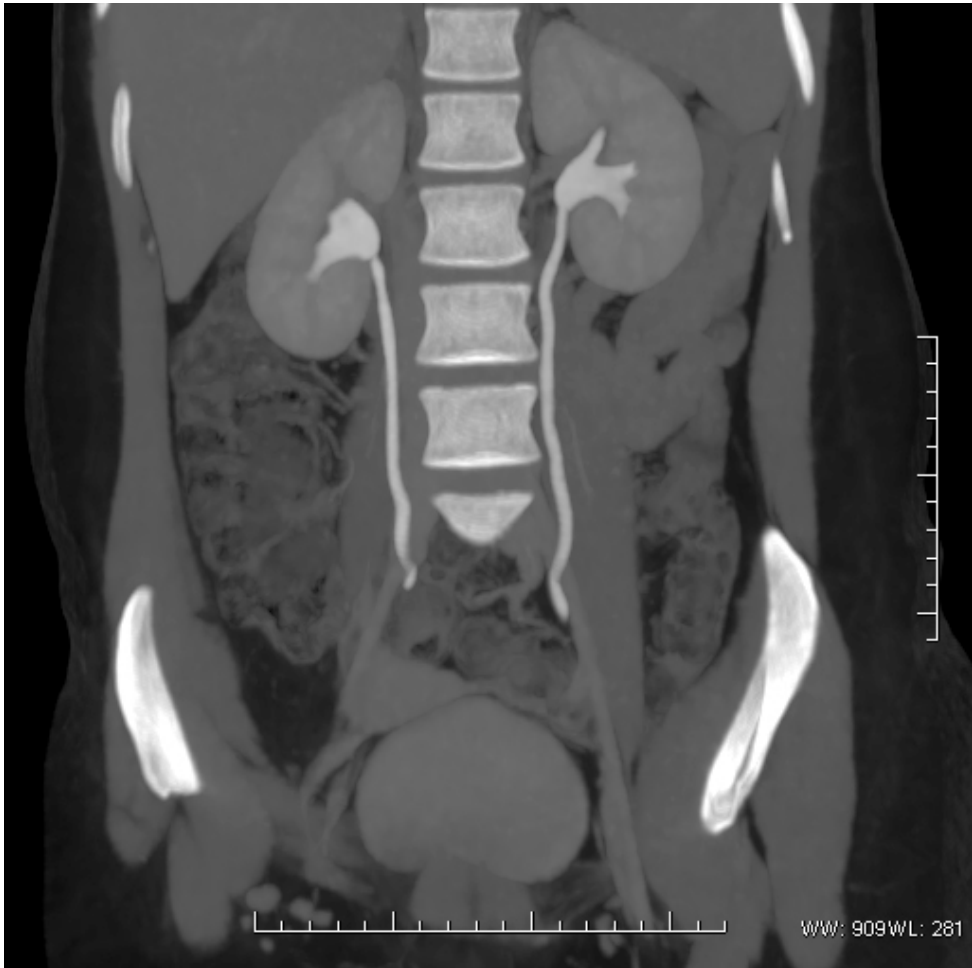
Split-bolus CT-Urography with MIP reconstruction allows evaluation of pelvicaliceal system and ureters fully distended, as well as renal parenchyma, in a potential kidney-donor.
